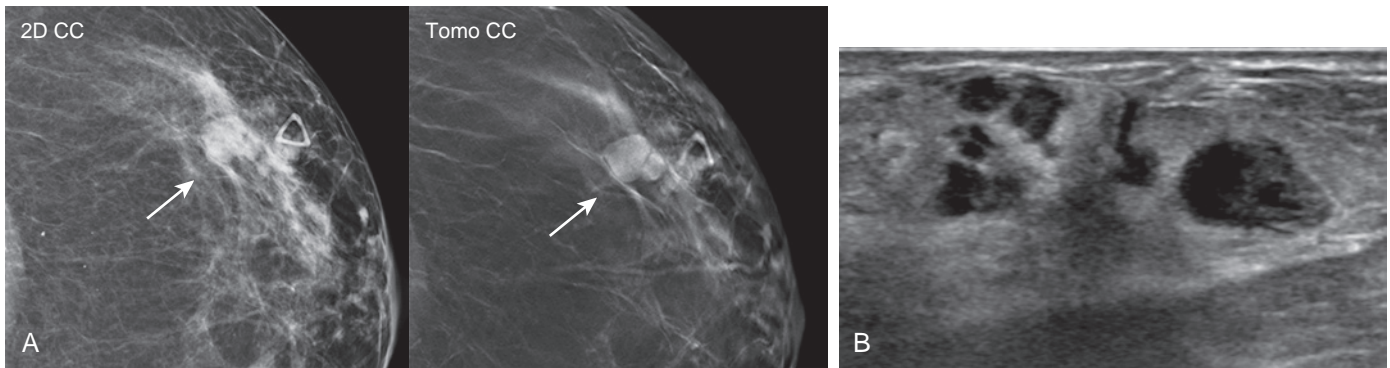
Metastatic disease to the breast. A 61-year-old woman with normal mammogram 2 months previously. She noted a new lump and spontaneous large bruise on her left breast. (A) Craniocaudal two-dimensional and tomosynthesis views demonstrate a lobulated mass corresponding to the clinical findings (arrows). (B) Ultrasound demonstrates a corresponding complex solid, multicystic mass with several adjacent additional hypoechoic lesions. Ultrasound core needle biopsy yielded metastatic melanoma.
